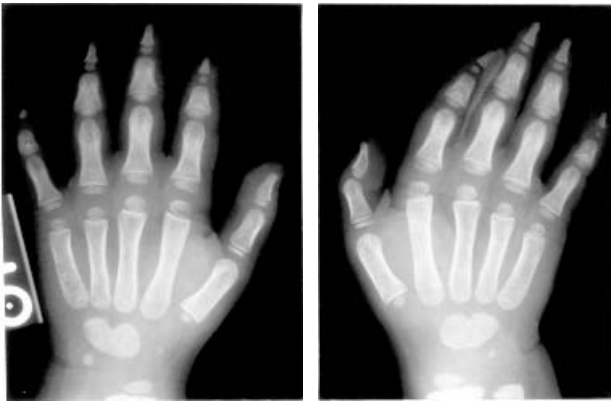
Radiographs of hands in Muenke syndrome. Brachydactyly with short thimble-like middle phalanges of the second through fifth fingers and fusion of the capitate and hamate bones of the wrists. (From Muenke and Wilkie [235]. Reprinted by permission of McGraw-Hill Companies Inc.)
